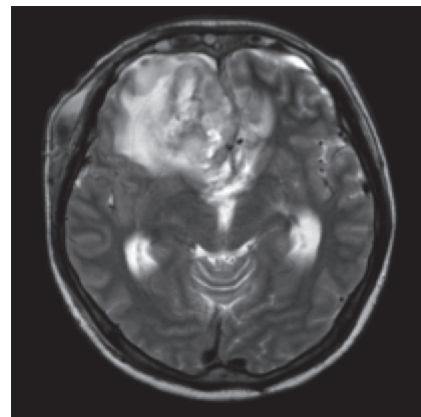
Brain MRI on 11th day after surgery
